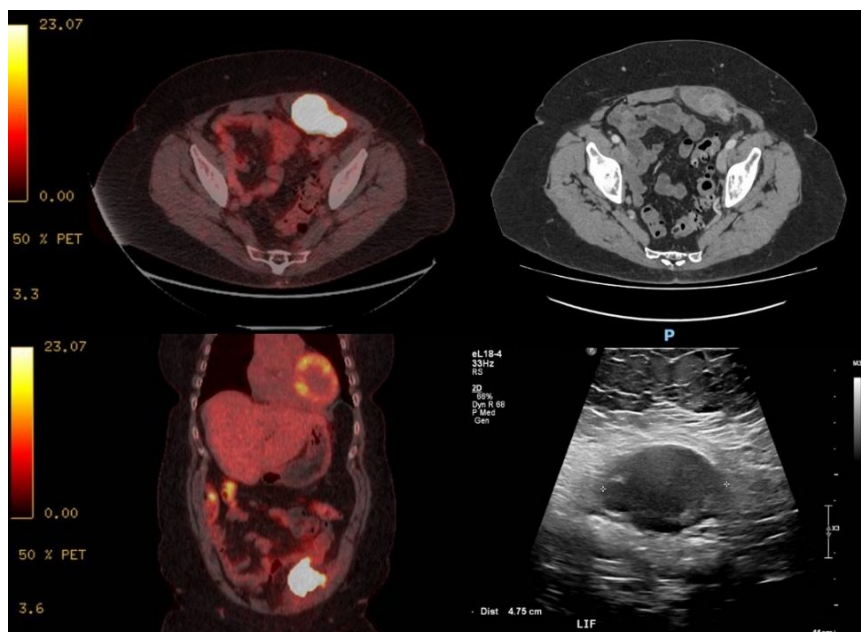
mass in the left rectus sheath (top left = axial PET CT, bottom left = coronal PET CT, top right = axial contrast CT, bottom right = trans-abdominal ultrasound).
